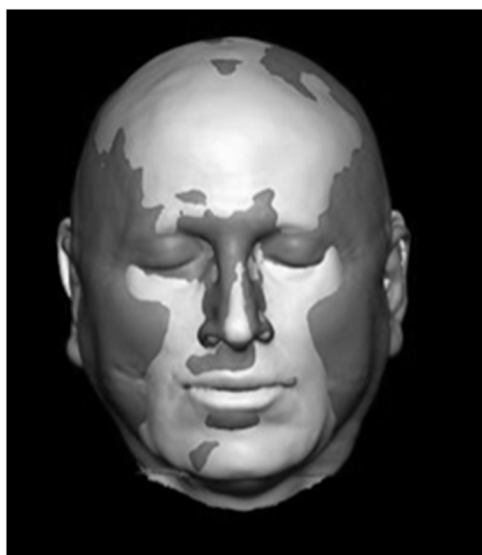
Screenshots of a 3D facial depiction (F - light) aligned to the donor CT model (dark).
